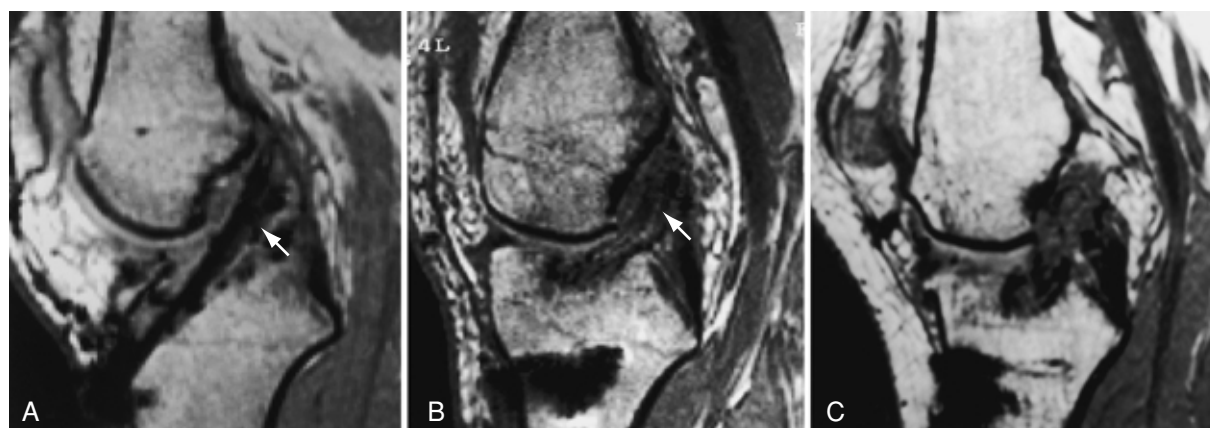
Sagittal images of ACL graft at 12 months after reconstruction (3-D MRI with field echo sequences, flip angle 45 degree, TR 51 msec/TE 14 msec).
